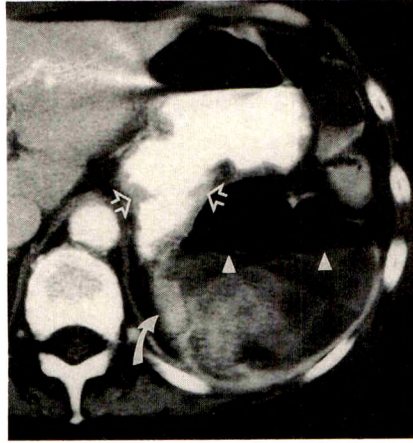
Abscess from local inflammatory process. A chronically ill man presented with sepsis. On CT scan, splenic parenchyma is replaced by infected collection with air-fluid level (arrowheads). This resulted from a benign posterior gastric ulcer (open arrows) that perforated spleen. High-attenuation material in splenic abscess (solid arrow) is oral contrast agent.
